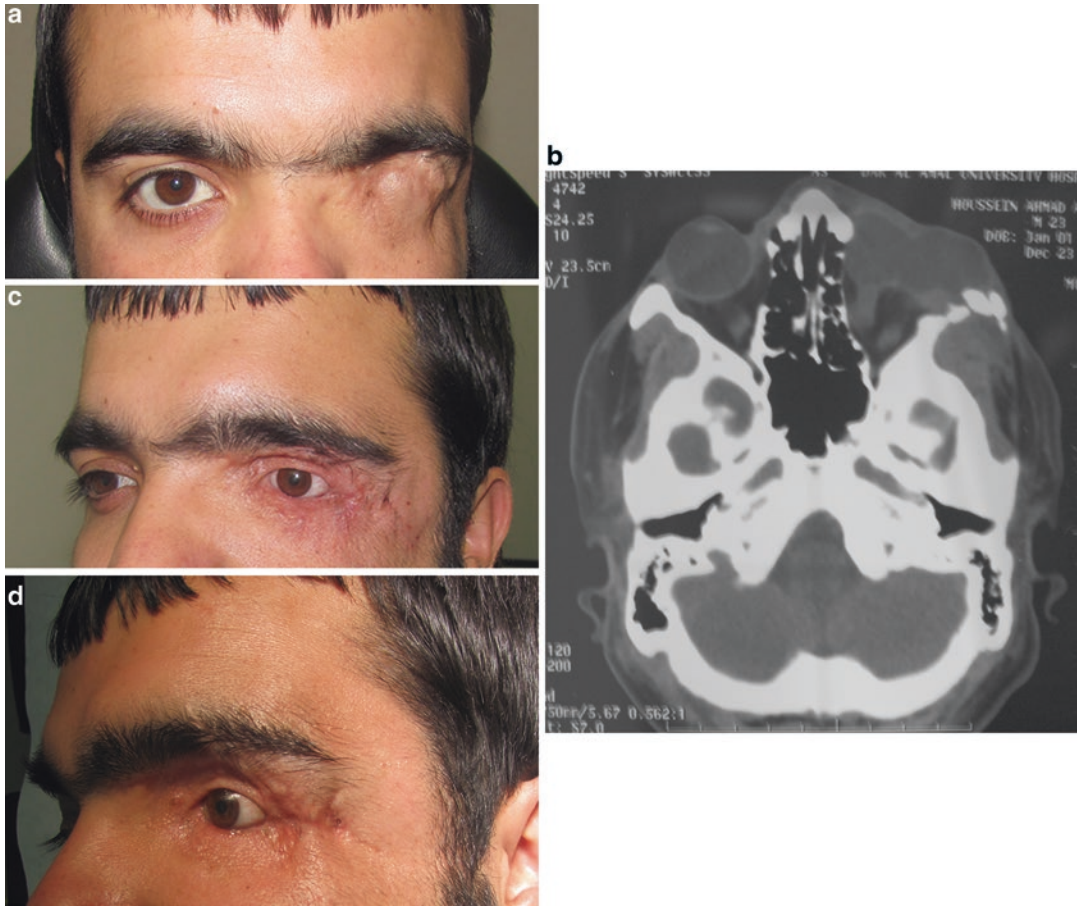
A 27-year-old male with skin bridging the area from the brow to the cheek (a). Computed tomography scan revealed a cystic structure extending from the medial to the lateral orbital rim (b). Panel (c) shows the patient
